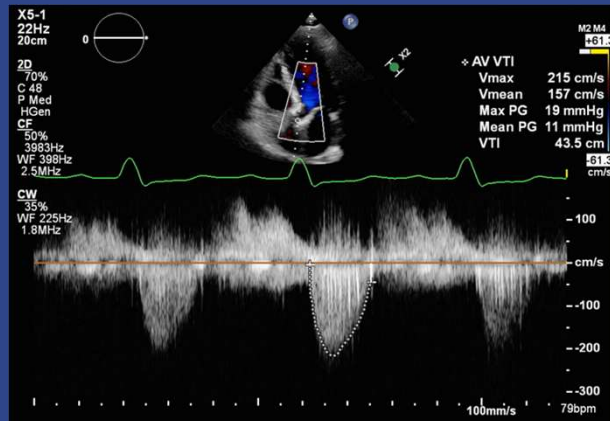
Apical CW Doppler across post-op day 30 TAVR, from author's clinical collection, di-identified (M.Trump, 2025)
